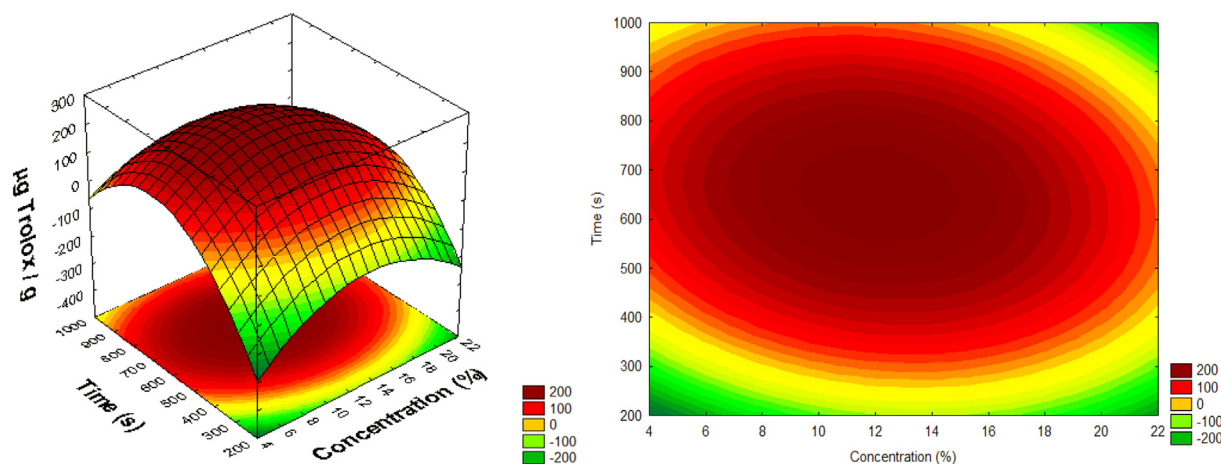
3D and 2D graphics for the effects of rosemary concentration and extraction time on the antioxidant capacity of chia oil enriched with different rosemary concentrations using the ultrasound-assisted extraction.
